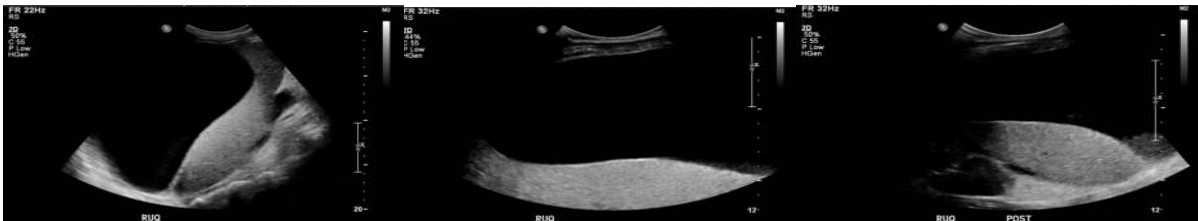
Large perihepatic fluid collection noted on ultrasonography
